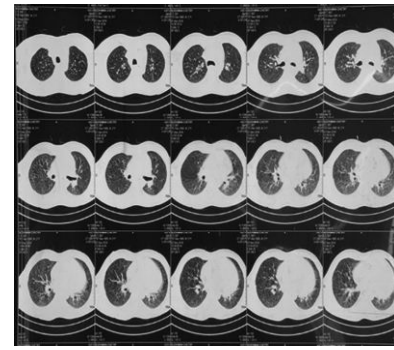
CT thorax showing para-hilar lymphadenopathy
